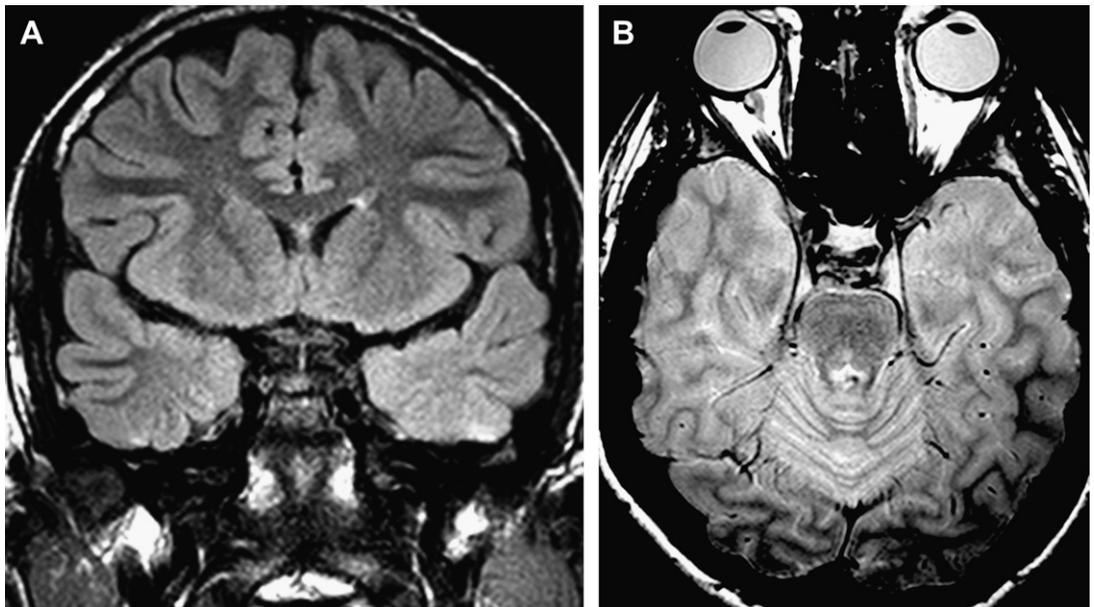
Left temporal FCD I. (A) Coronal FLAIR. As compared with the right side, the gyral digitations of low signal appear effaced on the left. (B) This is also apparent on this axial PD image.
